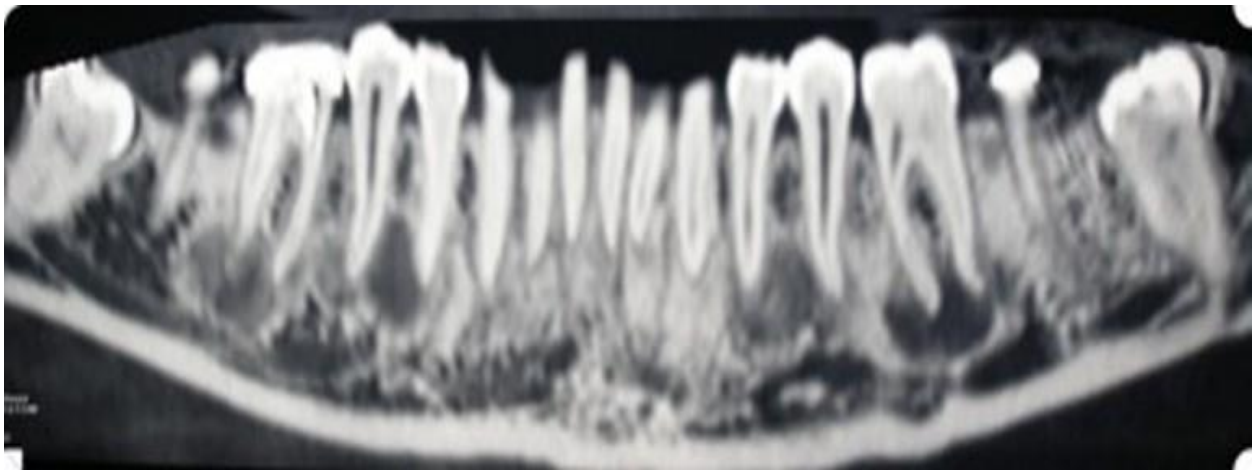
Computed tomography of mandible showing bilaterally symmetrical, well defined lesions of variable radiodensities in the apical region of posterior teeth.
